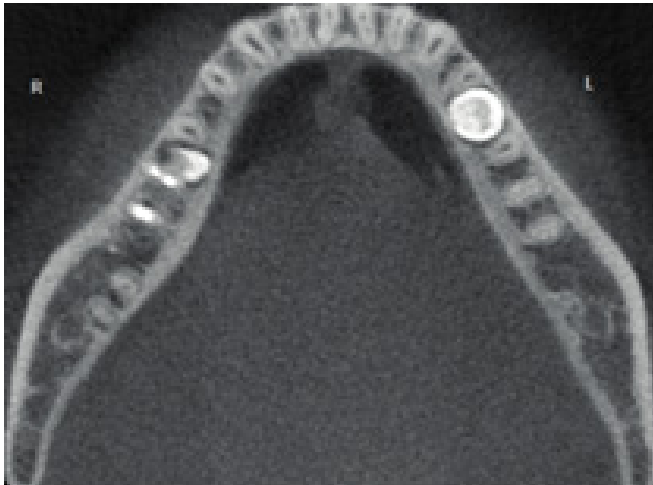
CBCT scan of Mandibular central incisor
